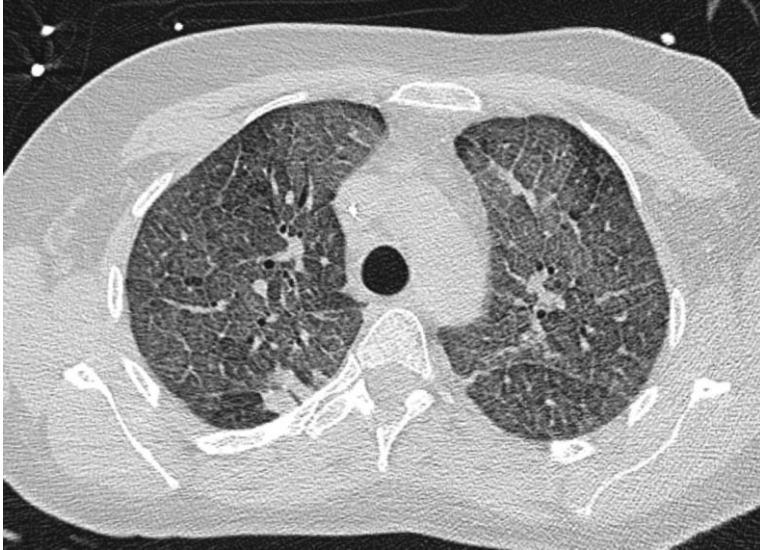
Chest high-resolution CT, lung window, shows diffuse interlobular septal thickening, GGOs (crazy-paving pattern), and a right upper lobe condensation.
